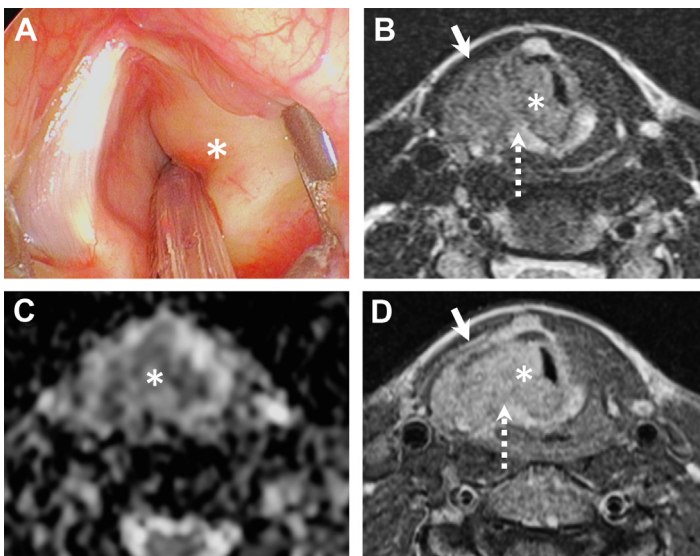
Rosai-Dorman disease manifesting as a submucosal laryngeal tumor. The patient presented with increasing dyspnea and slight changes in voice quality over 3 months. Endoscopic view (A) showing an entirely submucosal lesion involving the right hemilarynx and leading to major subglottic obstruction (asterisk). Axial T2 (B), ADC (C), and contrast-enhanced T1 (D) obtained at the subglottic level show an infiltrative lesion involving the right subglottic region (asterisk) with an intermediate signal intensity on T2 and restricted diffusion ($\text{ADC} = 0.7 \times 10^{-3} \text{ mm}^2/\text{s}$). Homogeneous and relatively strong enhancement is seen in D. The lesion invades the thyroid cartilage and there is extra-laryngeal tumor spread (arrows in B and D). Invasion of the right cricoid (dashed arrows in B and D). An enlarged level IV lymph node was equally seen (not shown). MR imaging suggested the probable diagnosis of lymphoma based on the low ADC, homogeneous enhancement, and the fact that the tumor was entirely submucosal. Biopsy revealed, however, Rosai Dorfman disease.
